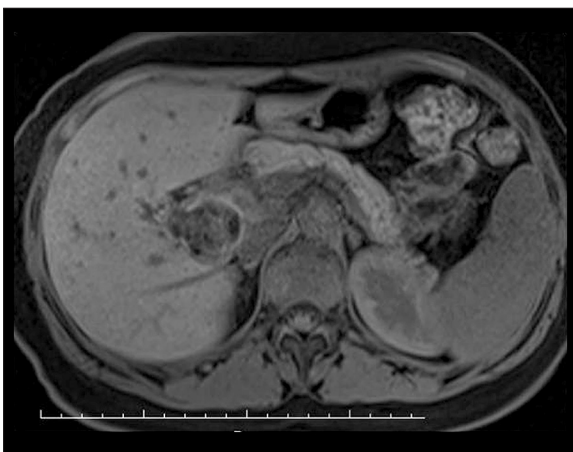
MR imaging shows a heterogeneous hypointense lesion at the level of the portal hilus in the liver on axial T1 fat-suppressed sequences.
